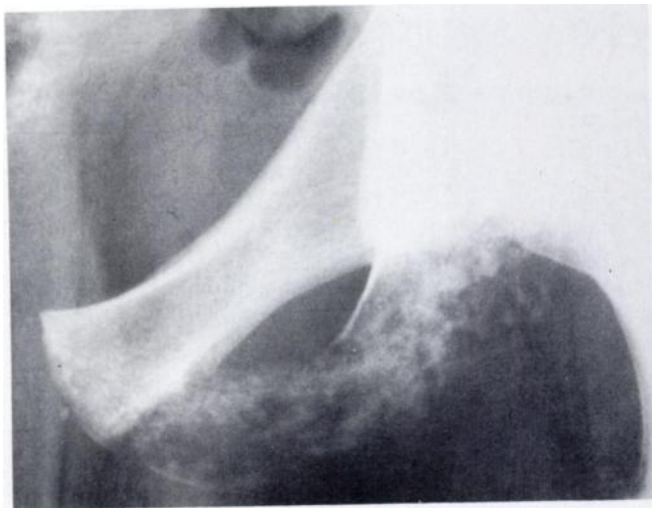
Moth-eaten destruction: radiographic pattern of a poorly circumscribed focal lesion which shows multiple, apparently randomly distributed holes which destroy the structural integrity of bone. The holes lack uniformity of size, ranging from those large enough to destroy the total thickness of cortex to those small enough to resemble those of permeated destruction. The pattern is extensively destructive and often responsible for pathologic fracture. [Osteomyelitis, Grade II.]
